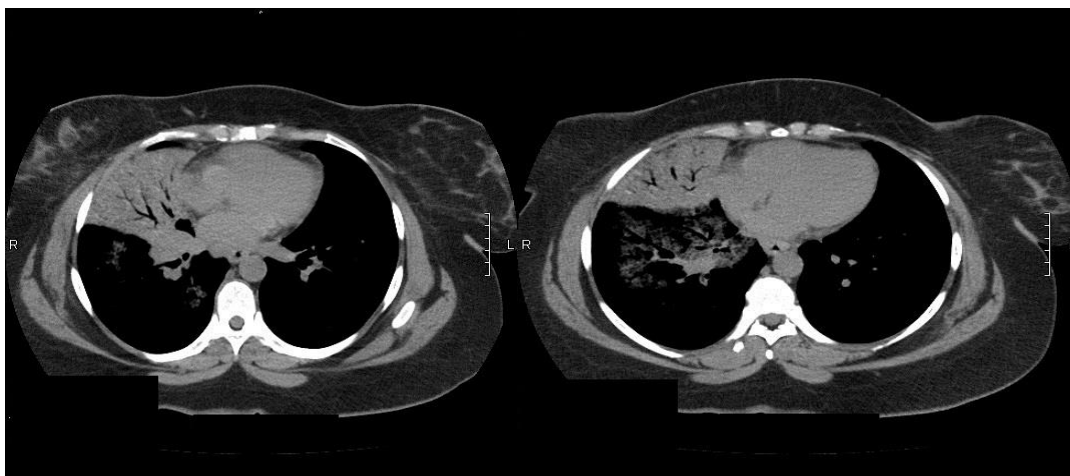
CT scan demonstrating mediastinal and right hilar masses and persistent complete consolidation of the right middle lobe. Note diffuse bilateral patchy opacities and micronodules.
